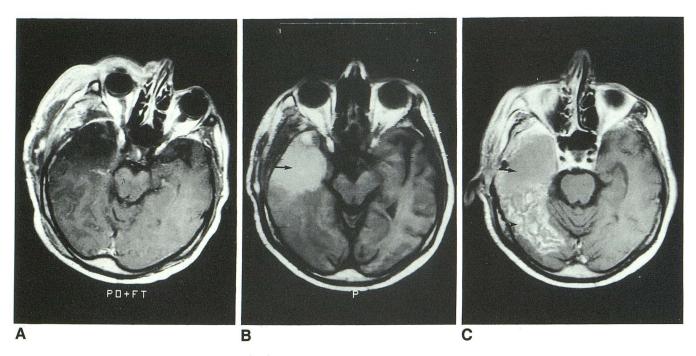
Axial T1-weighted MR images (600/20/2) obtained on second day (A) and during second week (B and C) after extirpation of glioblastoma.
